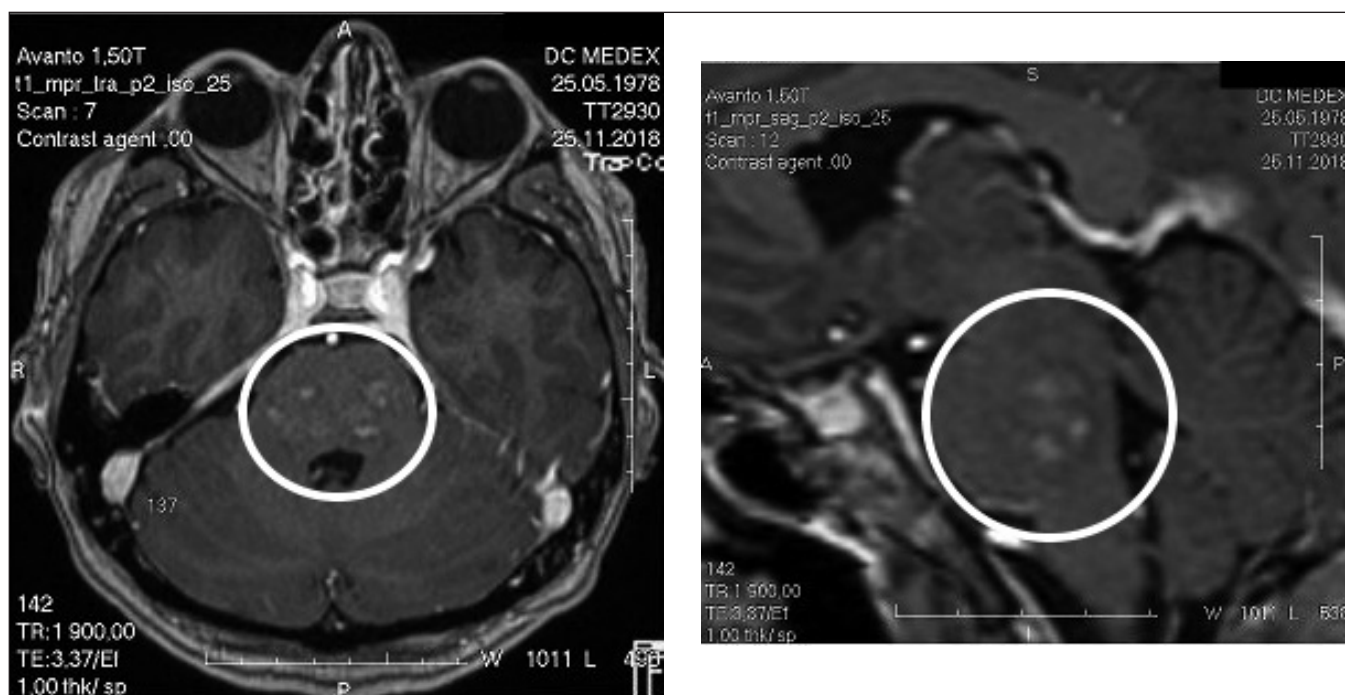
MR images at the post-gadolinium scans, heterogeneous accumulation of contrast in the structure of the indicated region is preserved.
